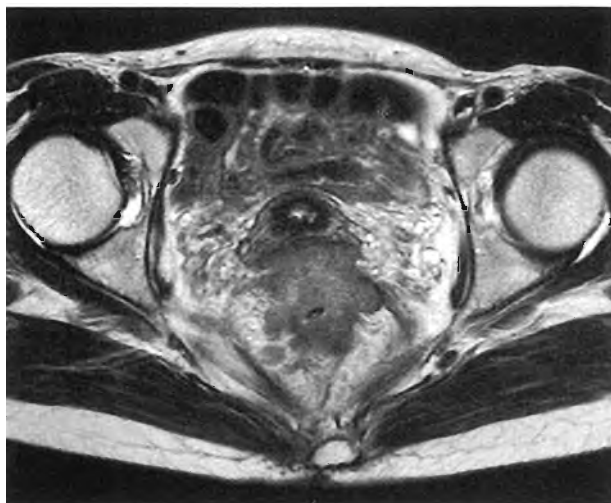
Case of T4b vagina cancer with the boundary lost due to tumor invasion (MRI: T2WI)
